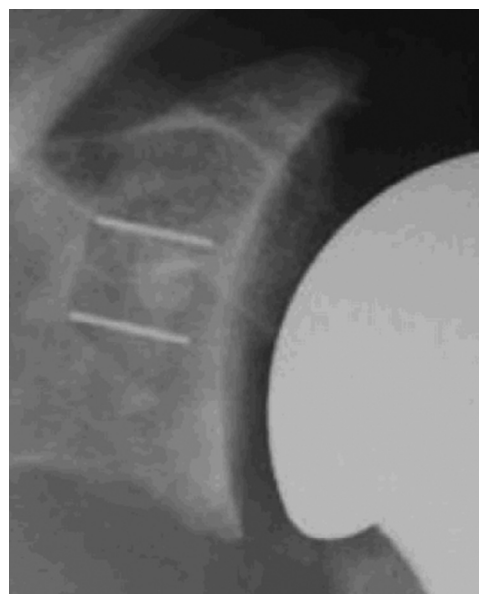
An anterior-posterior radiograph 3 years after surgery shows a cemented keeled glenoid component without radiolucent lines.
